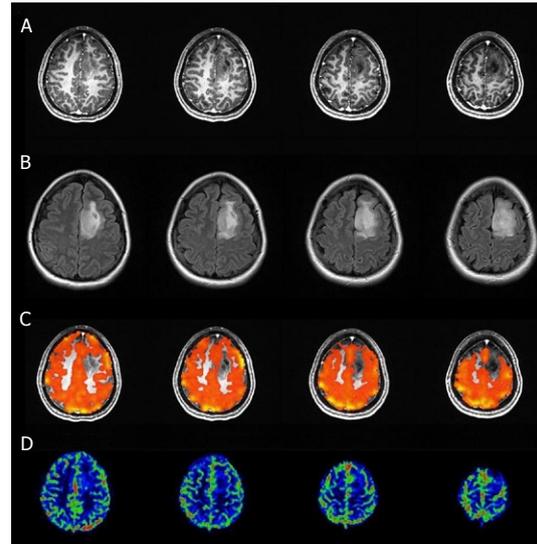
Axial T1 postcontrast 3D MPRAGE and T2 FLAIR images (A and B) breath-hold cerebrovascular reactivity maps (C) and relative cerebral blood flow maps (D) in a patient presenting with a left frontal lobe lesion, classified as grade II oligoastrocytoma after surgical resection, are displayed. Breath-hold cerebrovascular reactivity (BH CVR) maps were fused with axial T1 post Gadolinium images, and the threshold was set to 0.35 for blood oxygen level dependent PSC. Decreased CVR is present within and at the anterosuperolateral margin of the lesion (involving the infiltrated cortex of the left superior frontal gyrus) relative to contralateral hemispheric normal tissue. This represents an area of tumor-induced neurovascular uncoupling. Perfusion imaging did not provide equivalent information because the same area does not demonstrate any definite regional perfusion abnormality.
